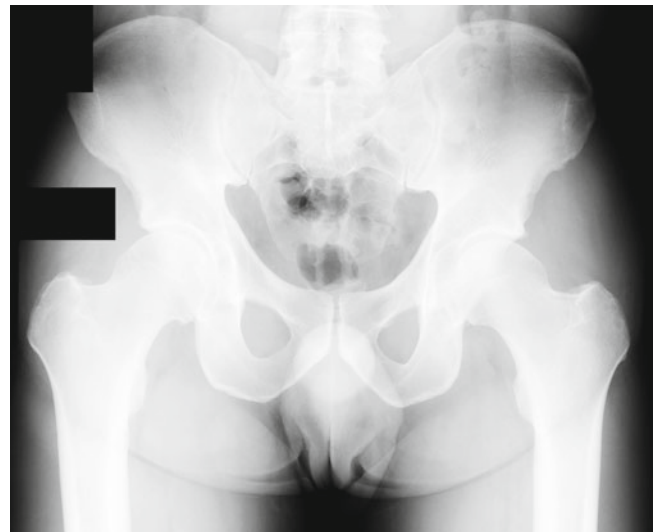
Anteroposterior radiograph of young man with bilateral impinging hips
